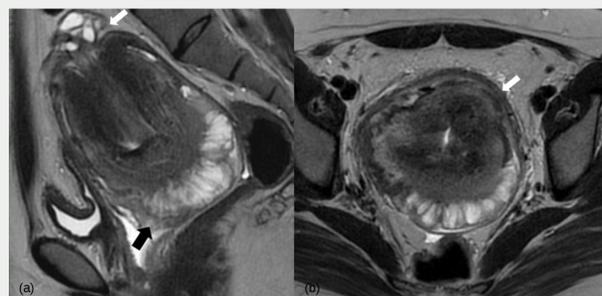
T2 weighted MRI images
